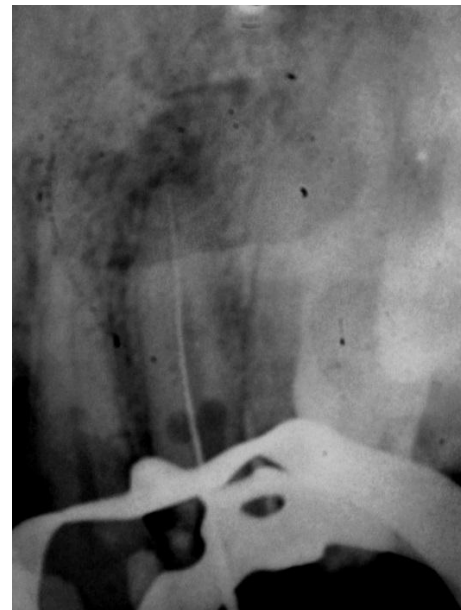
Radiographic odontometry
